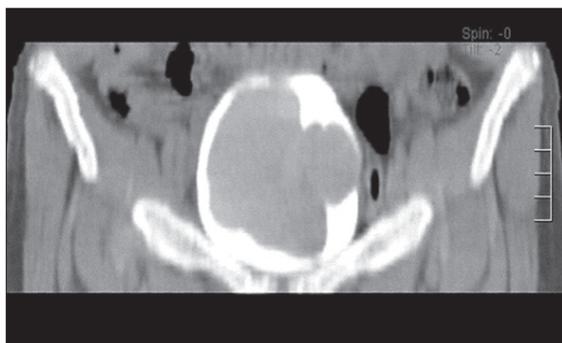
Coronal CT images showing 100 Hounsfield units density mass, arising from the anterior wall with a sessile stalk.
